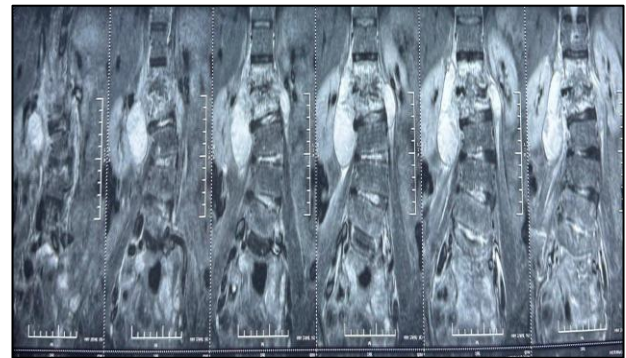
MRI Spine suggestive of thick collection in L2-L3.
